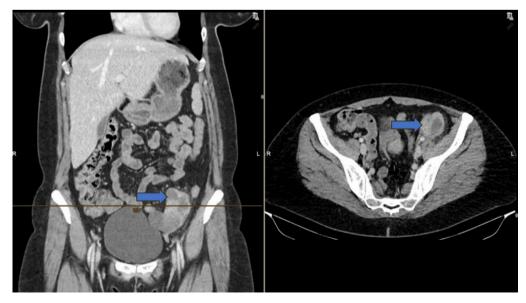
Abdominal CT scan. CT scan image, showing the left pelvic iliac tumour (see blue arrows). CT: Computed tomography.
